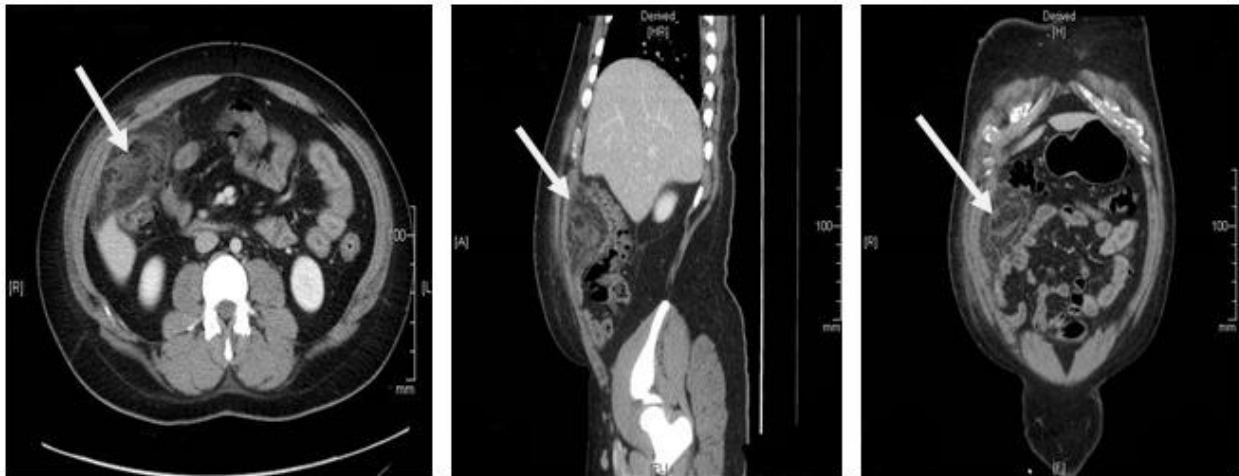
A CT scan images of abdomen upon admission
